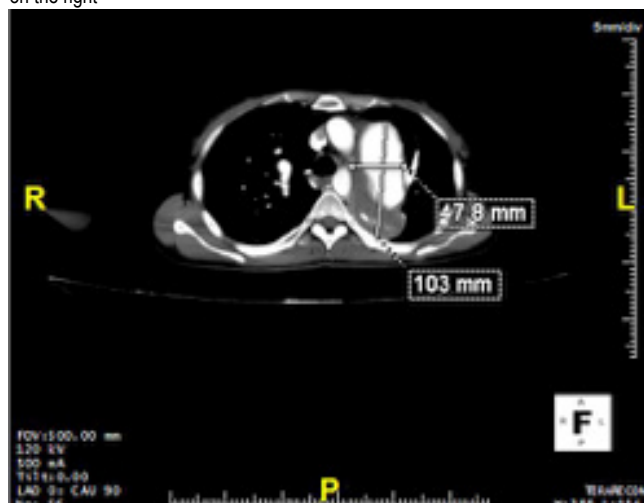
Axial CT scan of the chest at the level of the main pulmonary artery
